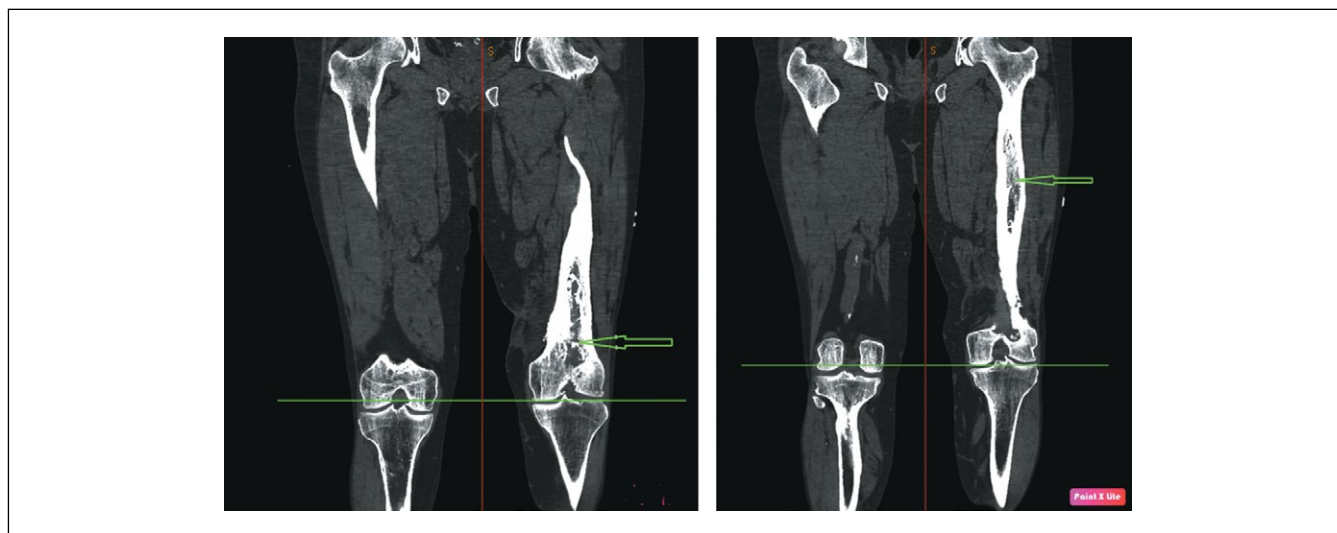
CT scan of the lower extremities, frontal projection. Arrows indicate the osteomyelitis focus.
